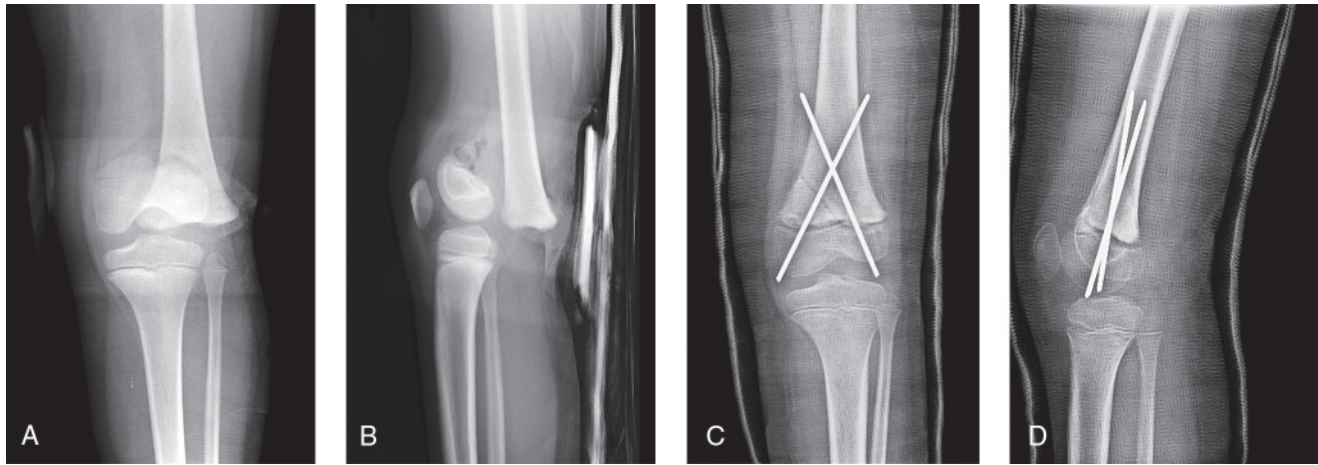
AP (A) and lateral (B) radiographs of a Salter-Harris type II fracture of the distal femoral physis in an 8-year-old girl. AP (C) and lateral (D) views of the fracture after closed reduction and percutaneous pinning in the operating room.
